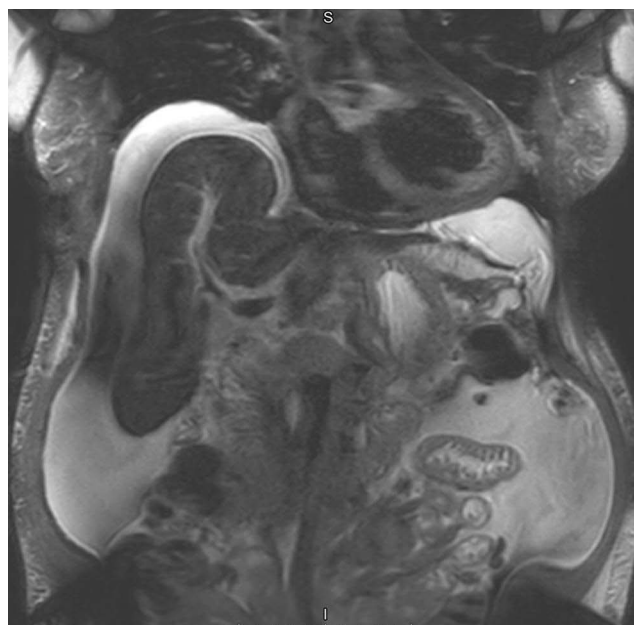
MRI follow-up 5 months postoperatively (February 2025). Findings indicate soft tissue consolidation in the postoperative area. Ascites is also noted.
